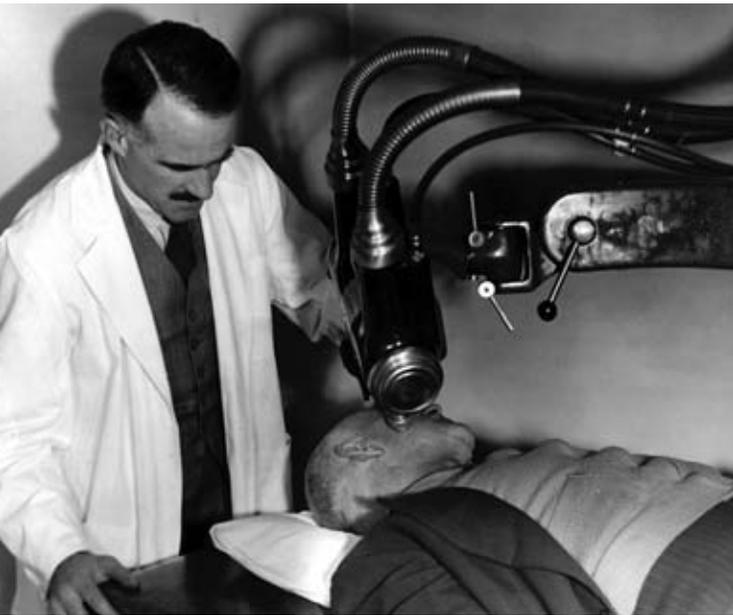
Dr Evans positions the 120KV X-ray unit for treatment of a skin cancer. Operational from 1947 until 1977, in its later years it “looked like a brave old soldier, with tape and bandages controlling an ever present oil leak”.
